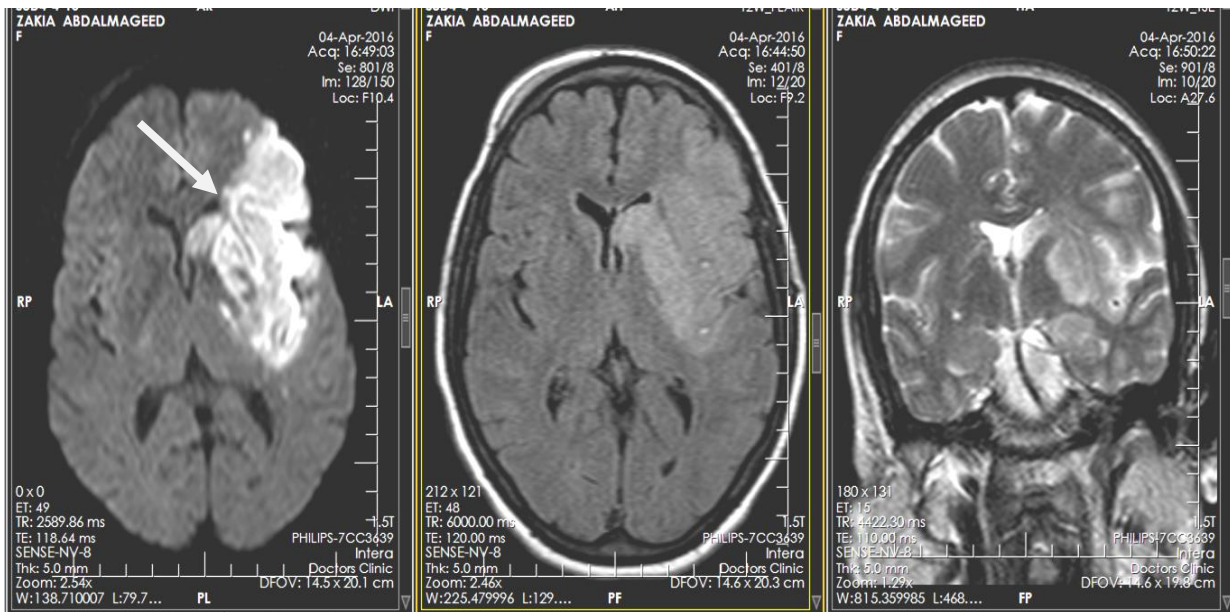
Axial MRI of the brain. Diffusion weighted imaging sequence showing left cerebral recent infarction for female patient 65 years old.
